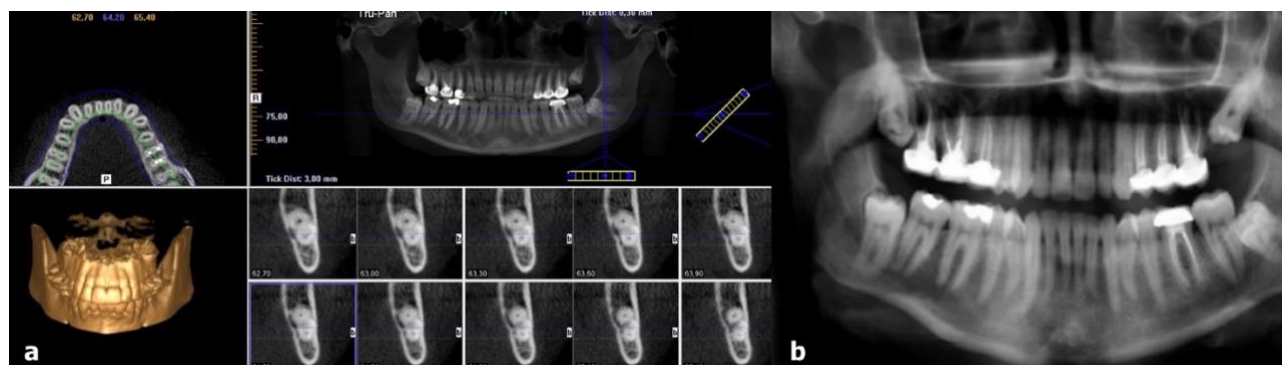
Cone-beam computed tomography (CBCT) and PR images of tooth no. 38. (a) The inferior alveolar canal (IAC) is lingually positioned and in contact with the inferior dental (ILTM root); (b) PR shows no white line interruption and no radiolucency at the root tip.
